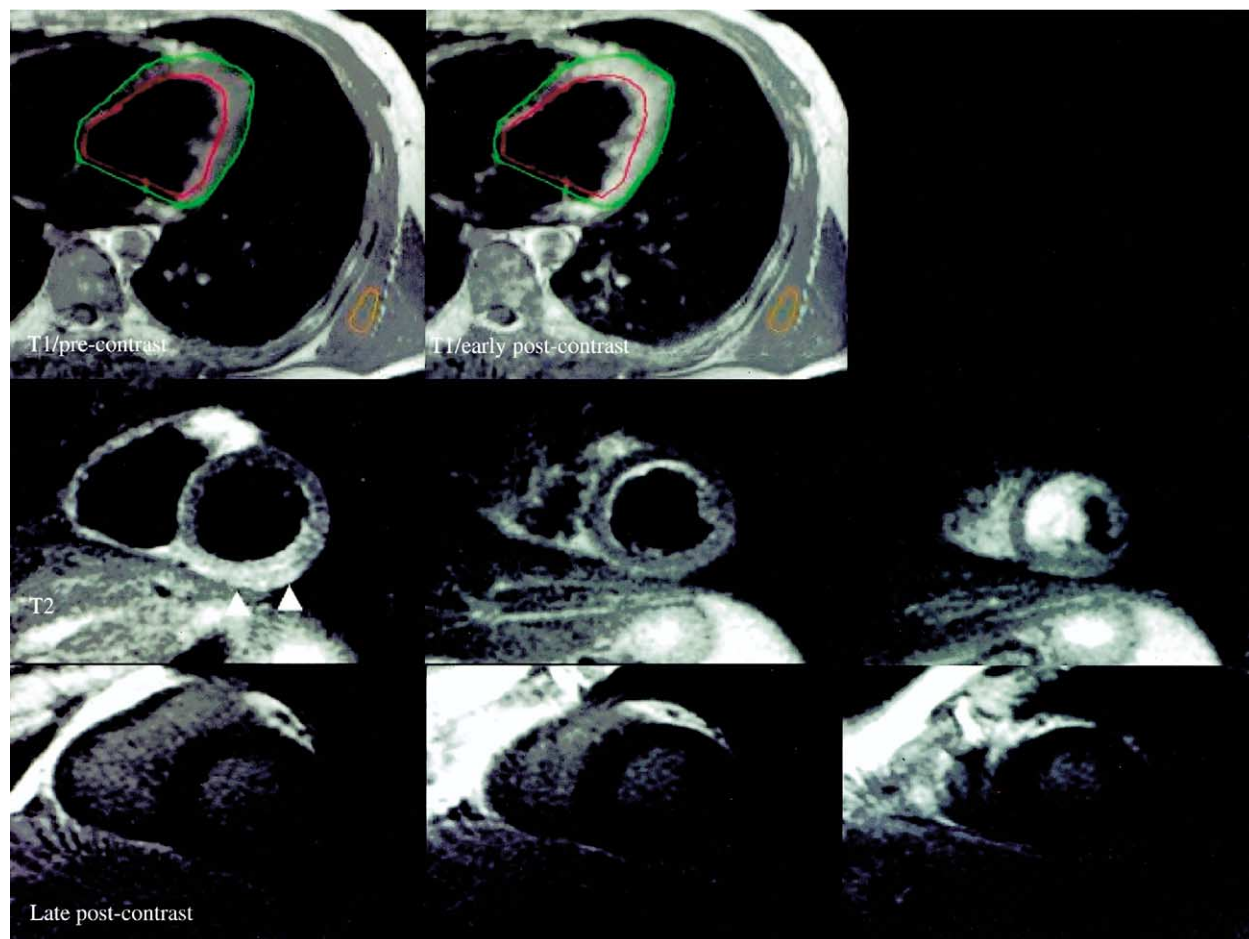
Cardiovascular magnetic resonance findings in Patient #21. (Top) Pre- and postcontrast axial T1-weighted spin echo images of the same slice. Global relative enhancement was elevated (4.1). (Middle) T2-weighted images in three short-axis slices. Note the posterolateral focal high T2 signal (arrowheads) in the basal slice with apparent focal increase in myocardial thickness. (Bottom) Corresponding late enhancement images: no evidence of late gadolinium enhancement.
